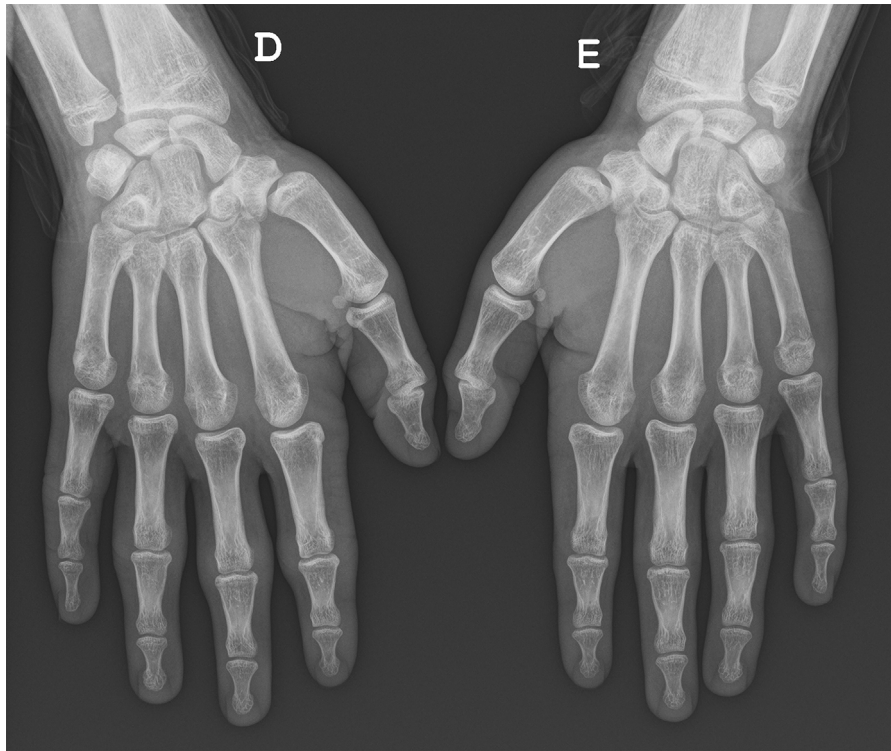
Radiograph of both hands.
